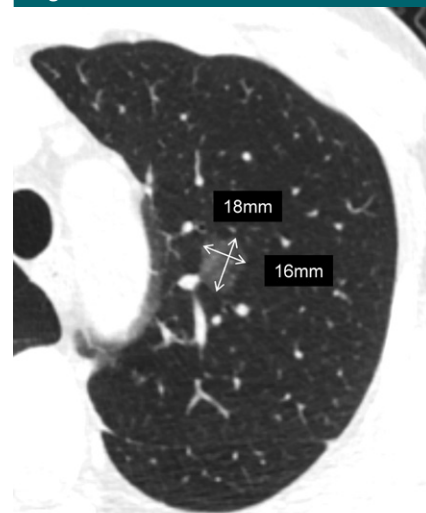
Transverse CT section of a pure ground-glass nodule in the left upper lobe. The same approach to nodule measurement described in Figure 2 applies in this image. The average diameter of the nodule is 17 mm.
